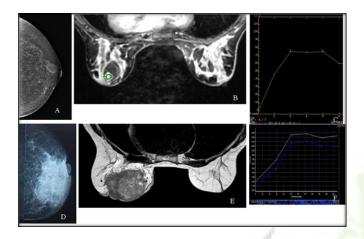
Patient-2: Intracystic Papillary Carcinoma. A. Left breast mammogram. B. DCE MRI-Post contrast axial T1W image C. kinetic curve. (patient 2) D.Patient 4. Inflammatory Ductal Cell Carinoma . Left breast mammogram. E. Pre contrast axial T2W image. F. kinetic curve.
